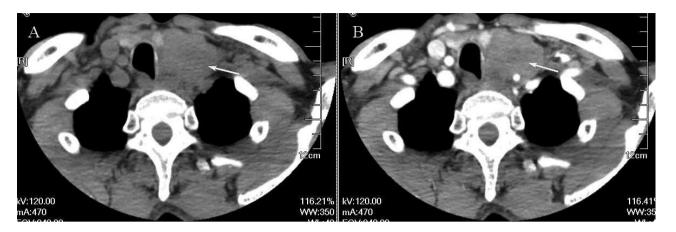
(A) Nonenhanced CT shows an isodense mass located in the lower pole of the thyroid gland. The mass displaced the trachea to the right side and involves the superior mediastinum. (B) On a contrast-enhanced CT, the corresponding lesion appears slightly enhanced.
